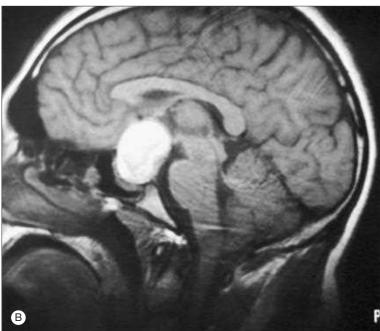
(A) Axial magnetic resonance imaging (MRI) view of enlarged apoplectic pituitary gland involving chiasm. (B) Sagittal MRI view from the same patient.
